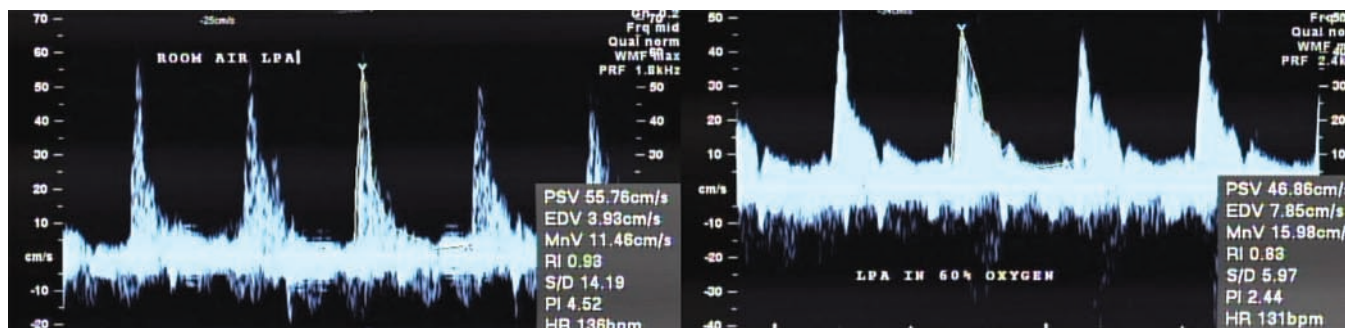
Positive change in Doppler flow patterns of pulmonary vascular reactivity with oxygen.
